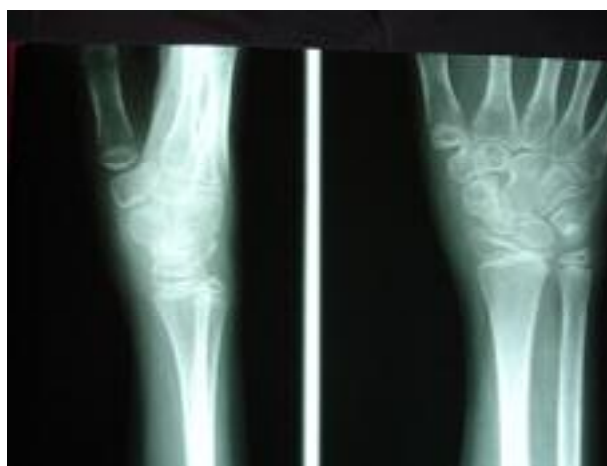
The first X-ray, two years before surgery
